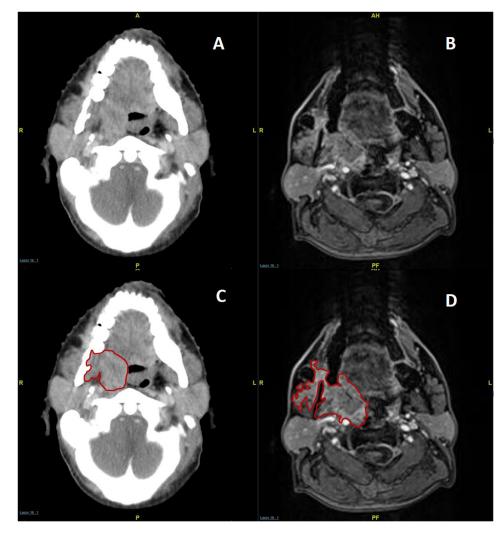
Lateral masticator space extension (involvement of masseter muscle) of tumor seen with better clarity on MRI compared with CT image. Axial section of CT scan (left side) post-iodine contrast (A: GTV not contoured and C: GTV contoured in maroon) showing right side tonsil tumor extending to right retromolar trigone, medial pterygoid with erosion of inner mandibular cortex. At the same level, axial section of T1- MR scan (right side) postgadolinium contrast (B: GTV not contoured and D: GTV contoured in maroon) showing right side tonsil tumor extending to right masseter muscle beyond right retromolar trigone, medial pterygoid, and with erosion of inner mandibular cortex. *Abbreviations:* CT = computed tomography; GTV = gross tumor volume; MRI = magnetic resonance imaging. (A color version of this figure is available at 10.1016/j.adro.2024.101453.)
